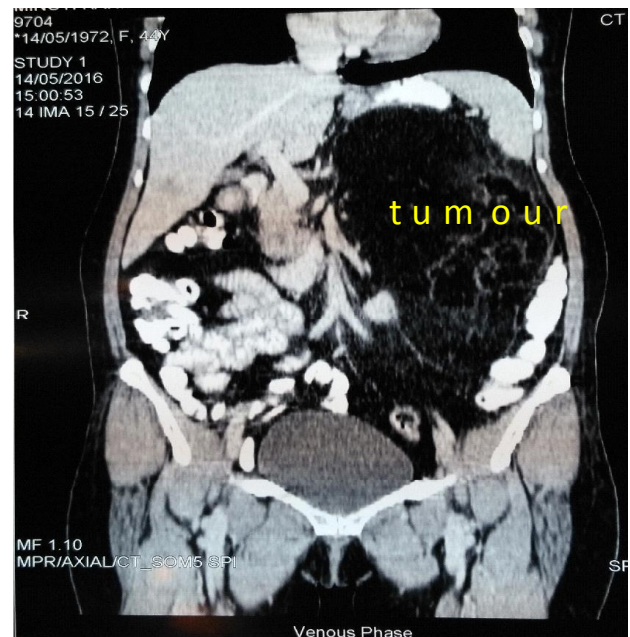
CT whole abdomen showing Giant left adrenal tumor
